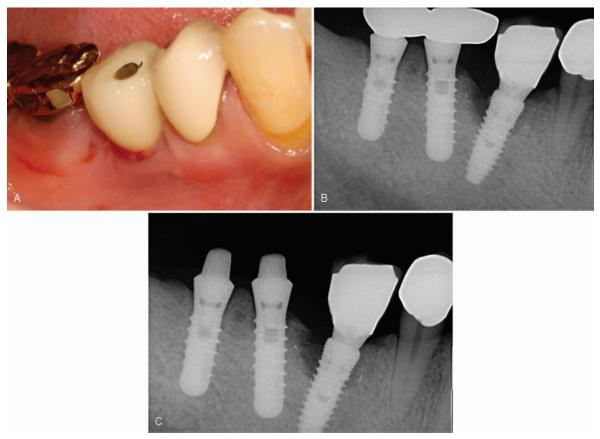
Evaluation of the peri-implantitis. (A) Buccal view showing bleeding upon probing and suppuration. (B) Periapical radiograph showing the loss of supporting bone around the dental implant. (C) Clinical photograph after nonsurgical approach.
